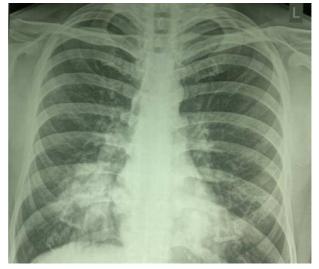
Chest radiograph-Response to ATT
